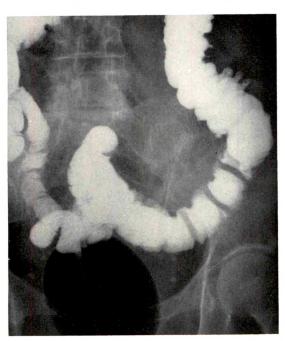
Filled barium enema roentgenogram. Some diverticula are present in the sigmoid colon. The Bardex bulb is fairly large.
